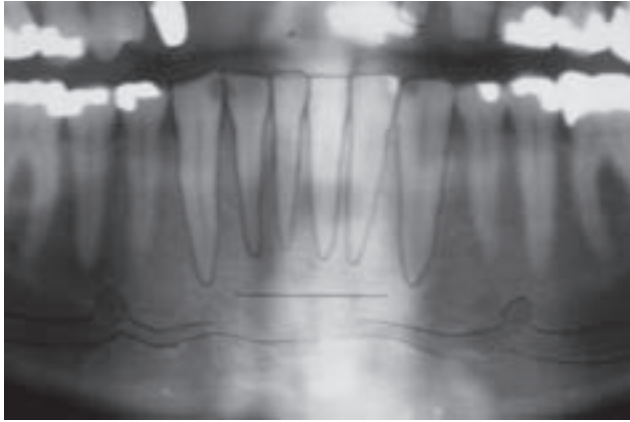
A panoramic radiograph reveals the incisive canal.
